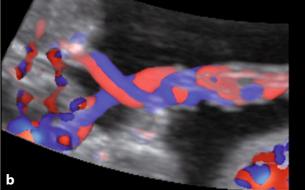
Monochorionic monoamniotic pregnancy: twins floating in the same sac (a); entanglement of umbilical cords with colour Doppler (b); true knots between the two cords (c)
